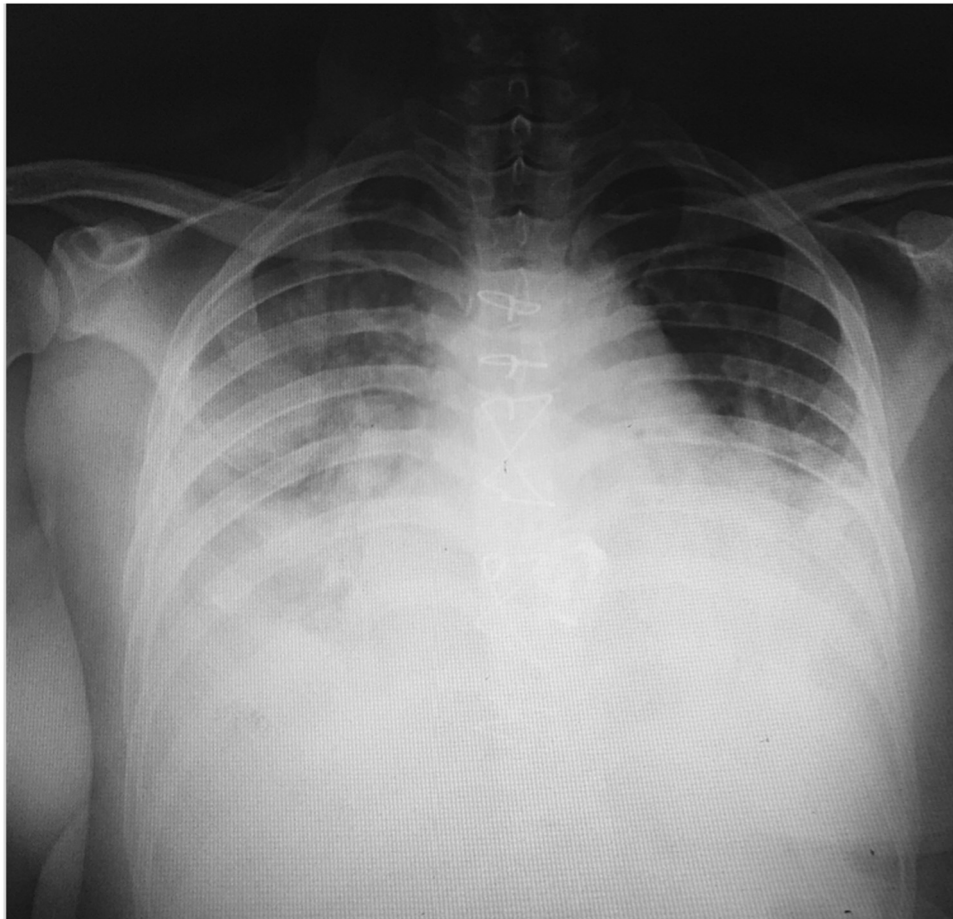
Chest X-ray shows bilateral pulmonary edema.
